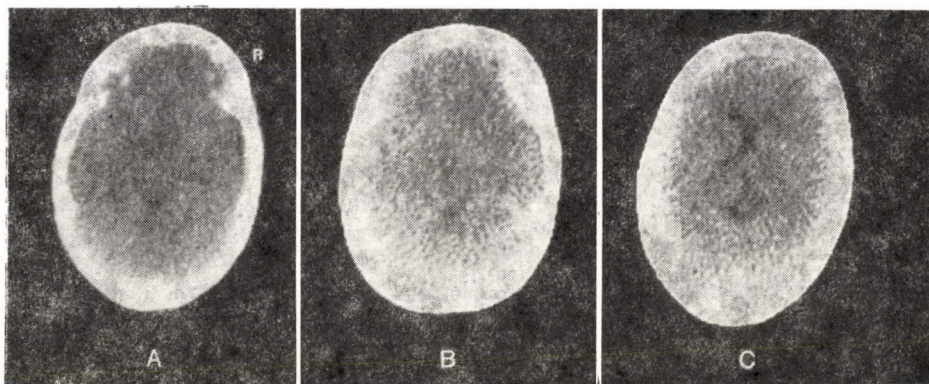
CT was made in a 2-year-old girl after a car accident. (A) 3 hours after the accident, (B) 2 days later; (C) 5 days later. The course of development and elimination of the haematoma are demonstrated. It is the type of disease where operation was avoided
